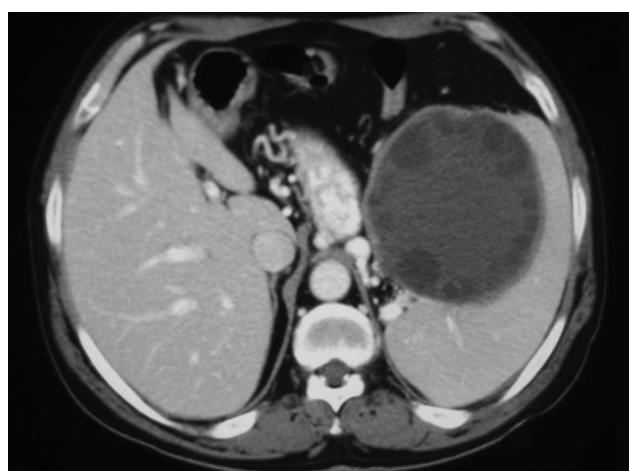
Abdominal CT scan revealed tortuous collateral vascular structure in gastric fundus region caused by hydatid cyst located in the splenic hilus.
